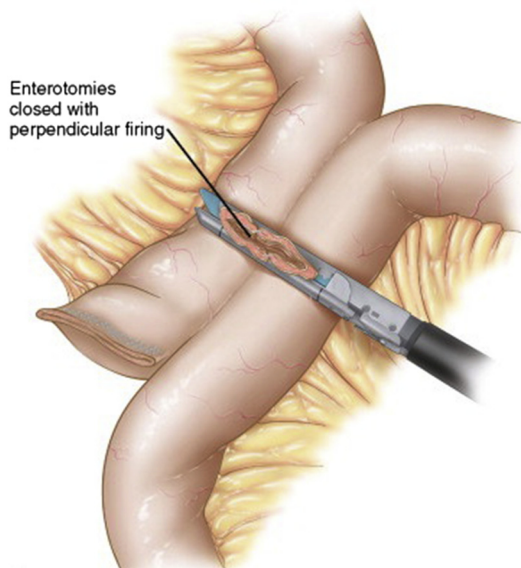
A white 2.5-mm staple load is used to close the remaining enterotomy and restore bowel continuity. (From Zografakis JG, Frantzides CT. Laparoscopic Gastric Bypass with Roux-en-Y Gastrojejunostomy. In: Frantzides CT, Carlson MA, editors. Atlas of Minimally Invasive Surgery. Philadelphia: Elsevier Saunders; 2009. p. 53–66; with permission.)
